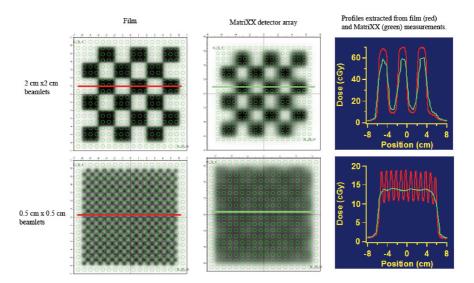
IMRT example demonstrating volume averaging for a 2D detector array compared to radiographic film. The measurements are shown with an overlay of the detector positions. An example of the profile is extracted from the film and detector array measurements to show the degradation of the detected signal (or blurring) due to the size of each chamber compared to the high spatial resolution film measurement).
